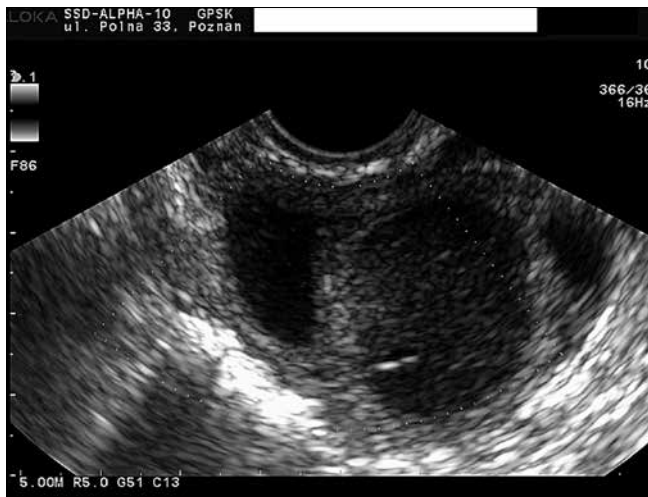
False negative result of ultrasonography in 32-year-old woman with borderline mucinous tumor.
